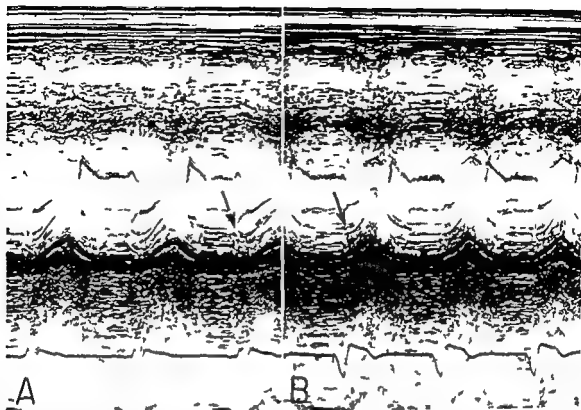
Echocardiogram of a patient with left ventricular hypertrophy A During sinus rhythm a VAW is present (arrow) B Same position as in A The VAW is absent (arrow) during right ventricular pacing at a slightly faster rate than in A
